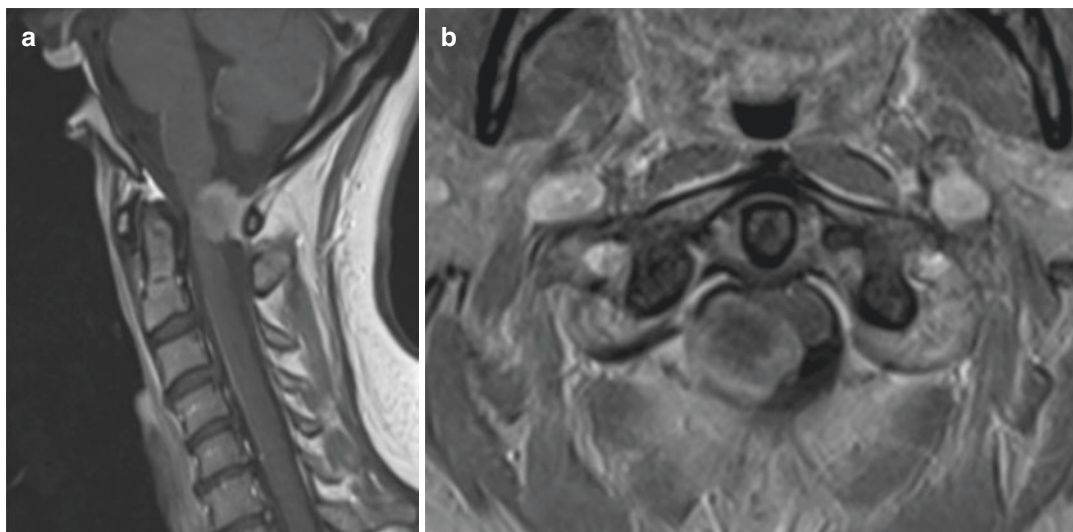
(a) Postcontrast T1-weighted sagittal and (b) axial magnetic resonance imaging (MRI) demonstrates tumor and brainstem compression in the right dorsolateral
